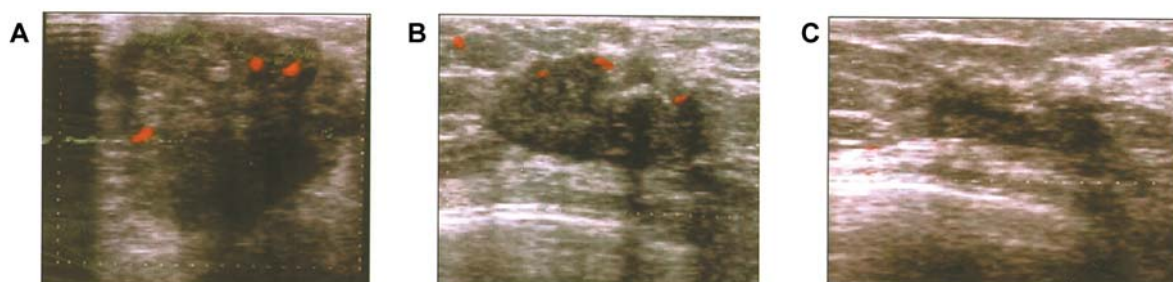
Carcinoma of the breast: color-Doppler ultrasound. A) Baseline: grade 1 vascularization. B) After two cycles of chemotherapy: moderate peripheral vascular signals. C) After four cycles of chemotherapy: no evidence of vascular spots.
